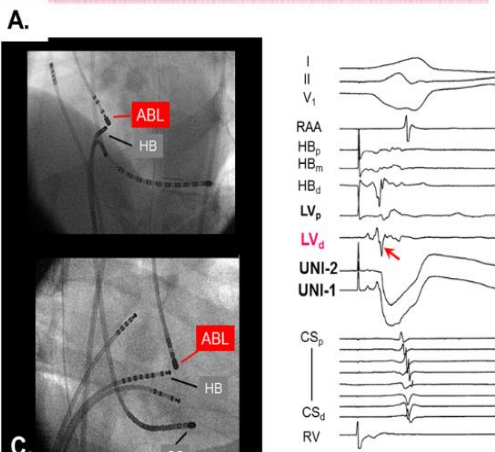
An AP located at the bottom of the noncoronary cusp. A. If the atrial activation timing is early behind the tendon of Todaro (hatched red area), it should alert the operator that the AP may be located in the left anteroseptal or left midseptal area (hatched yellow area) because mitral valve is less apical than the tricuspid valve. B. When the mapping catheter was pulled back from the anteroseptal LV (left beat) to the noncoronary cusp (right beat), a sharp potential (potential-X, red arrow) was recorded. Note that the local ventricular potential was a very late far-field potential, indicating that the ventricular insertion of this AP was distant from the noncoronary cusp. C. Radiographs show the location of the ablation catheter. D. During atrial pacing at a cycle length of 580 ms, a ventricular extra-stimulus (S<sub>2</sub>) was delivered, which advanced the ventricular potential by 70 ms without affecting potential-X. This observation indicated that potential-X was not a local ventricular potential. E. An earlier ventricular extra-stimulus advanced potential-X by 20 ms without affecting the local atrial potential, indicating that potential-X was not a local atrial potential. Potential-X was therefore an AP-P. F. Ablation there led to loss of the AP-P and loss of preexcitation. Modified with permission from *Circulation* 2007;115:2465-2478.
